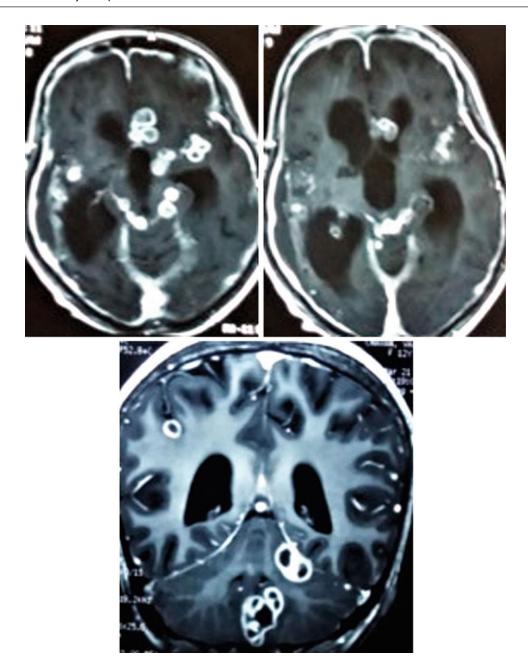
Multiple tuberculomas with significant hydrocephalus. Axial and coronal post-contrast MR images
